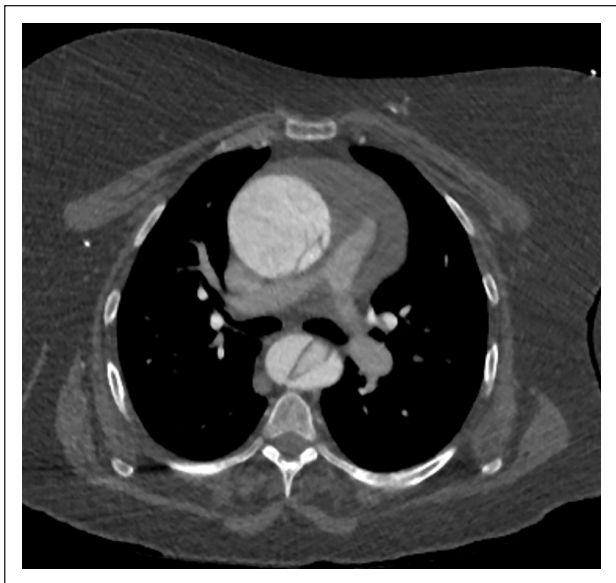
CTA axial section showing extension of the dissection to involve both ascending and descending aorta.
